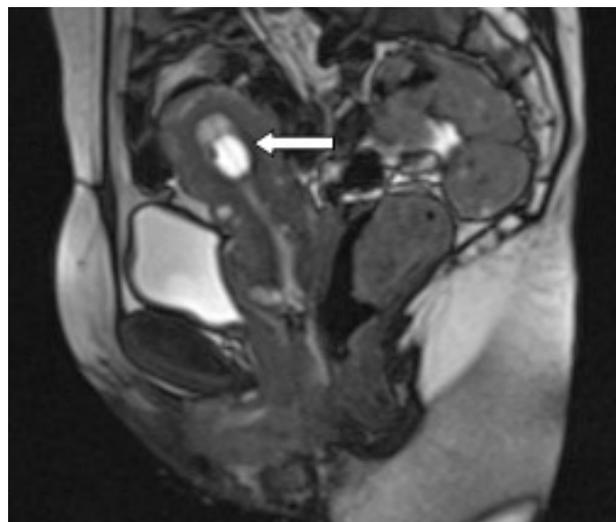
Sagittal T2-weighted HASTE. Correct intracervical position of the inflated balloon (arrow).
